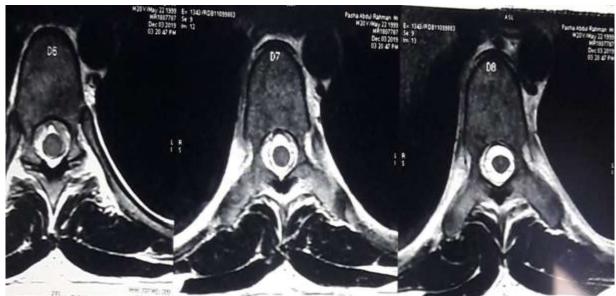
(b):- MRI of dorsal spine with contrast showing soft tissue mass from D6 to D8 producing gross compression over the spinal cord.
